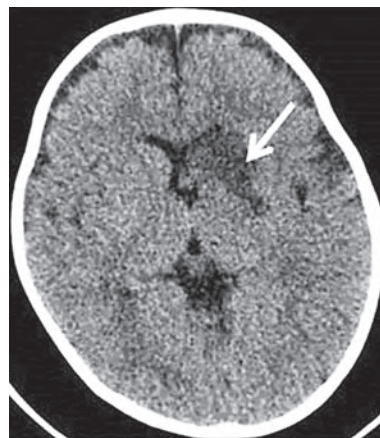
CT brain plain shows a large suprasellar predominantly cystic craniopharyngioma (red arrow in A) and foci of calcification within the lesion (yellow arrow in A) with features of obstructive hydrocephalus (white arrow in B)
